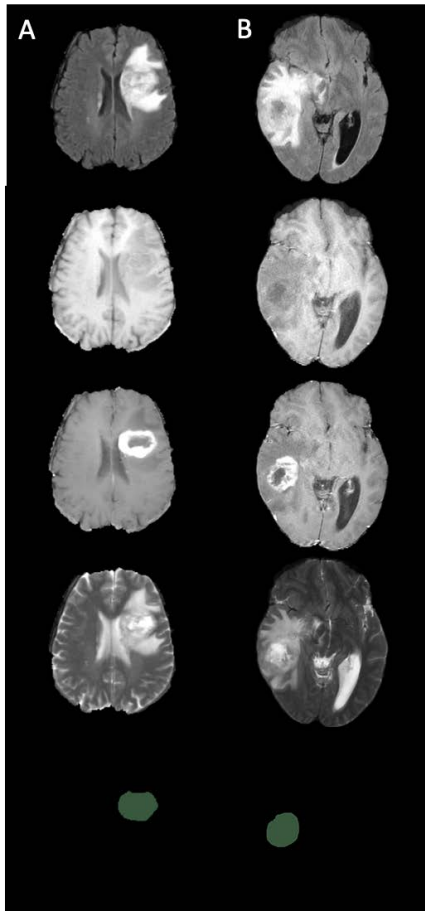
Example of A) TC delineation from the BraTS dataset and B) GTV delineations from the STORM_GLIO dataset. From top to bottom modalities; T1, T1ce, T2 and T2-FLAIR and Reference contour.
